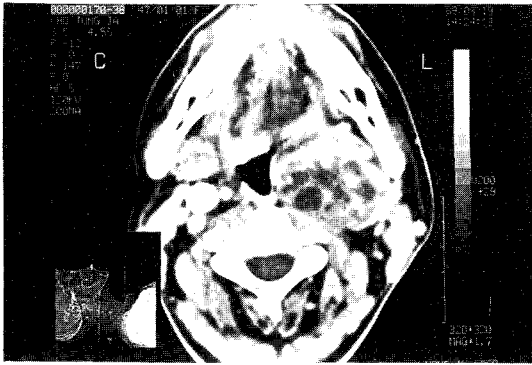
Case 4 : Axial CT scan showing a low density mass occupying the left parapharyngeal space. Note a pronounced bulging into the oropharyngeal area.
